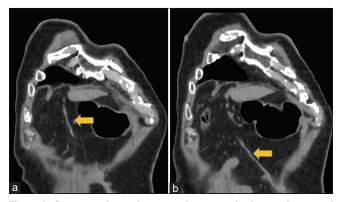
Contrast-enhanced computed tomography images in coronal sections (a and b) show the course of hepatic falciform artery extending from the falciform ligament up to the anterior abdominal wall (solid arrows)
